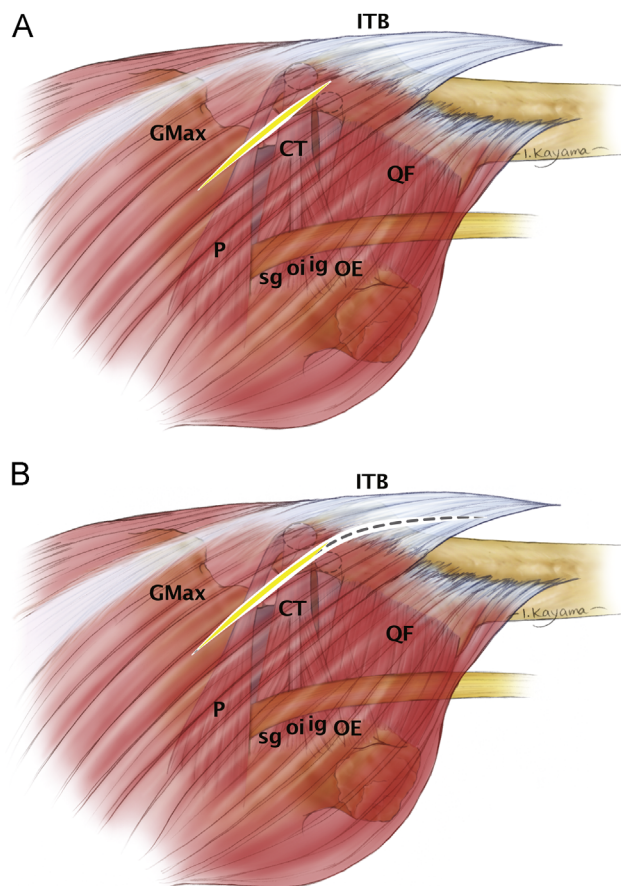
Skin incision for direct posterior. (A) The incision for the Direct Posterior[™] approach (yellow, ITB intact) begins at a point approximately 1 cm distal to the posterior corner of the greater trochanter. It is directed posteriorly, 45° to the long axis of the patient. It typically spans a distance of approximately 10 cm. (B) For the beginner, carrying the DP[™] incision more distally immediately provides access to a more familiar landscape. The surgeon who is new to this approach has the opportunity to stay in his or her comfort zone at all times. It is possible to scale down as comfort and patient safety dictate. ITB—iliotibial band, GMax—gluteus maximus, CT—conjoined tendon, P—piriformis, sg—superior gemellus, oi—obturator internus, ig—inferior gemellus, OE—obturator externus, QF—quadratus femoris. (c) Brad L. Penenberg
